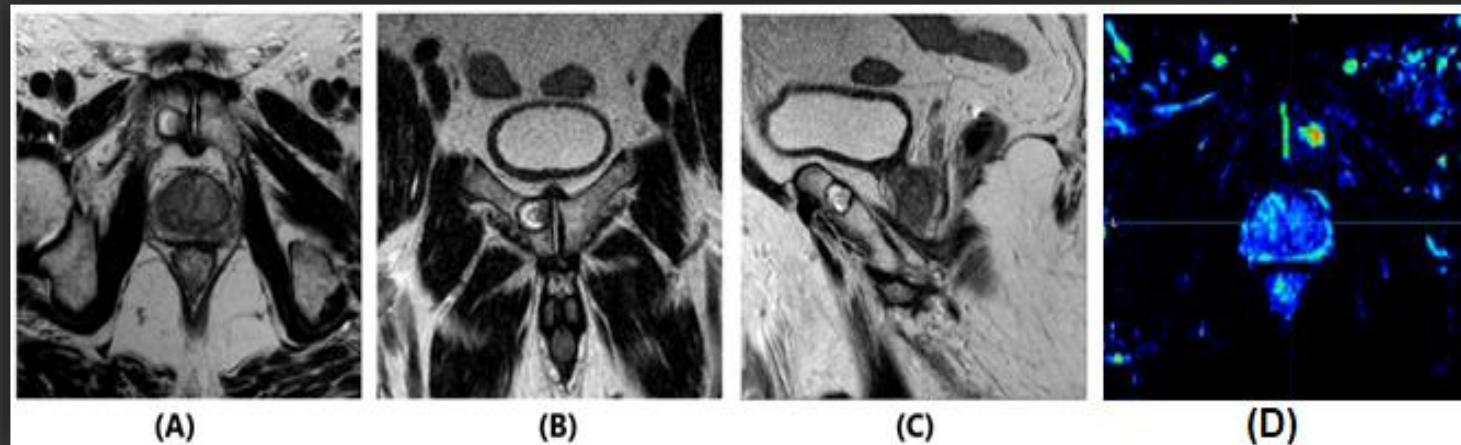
T2-weighted MR images in axial (A), coronal (B) and sagittal (C) planes and T2-mapping (D)
